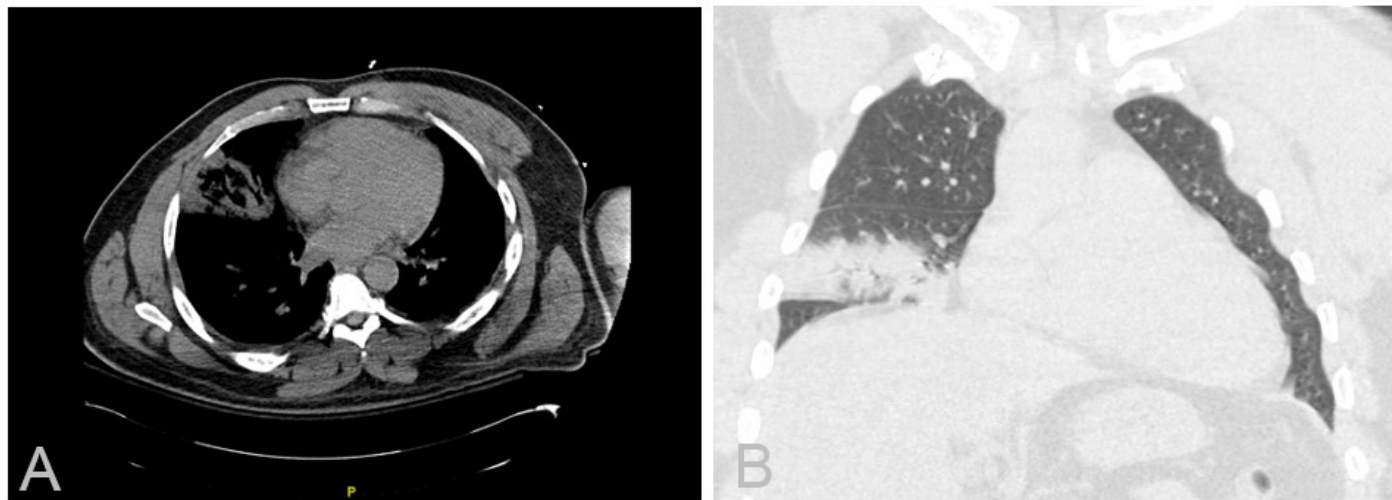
CT Chest imaging done on admission (A) Axial soft tissue windows demonstrating right middle lobe consolidation. (B) Sagittal lung windows demonstrating right middle lobe consolidation.
